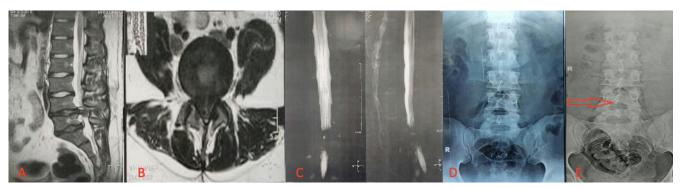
A) & B) MRI showing massive/huge LDH C) Myelogram showing complete myelographic block D & E) Post-operative Xray lumbosacral spine was compared to the pre-operative showing that bony work was minimal.
